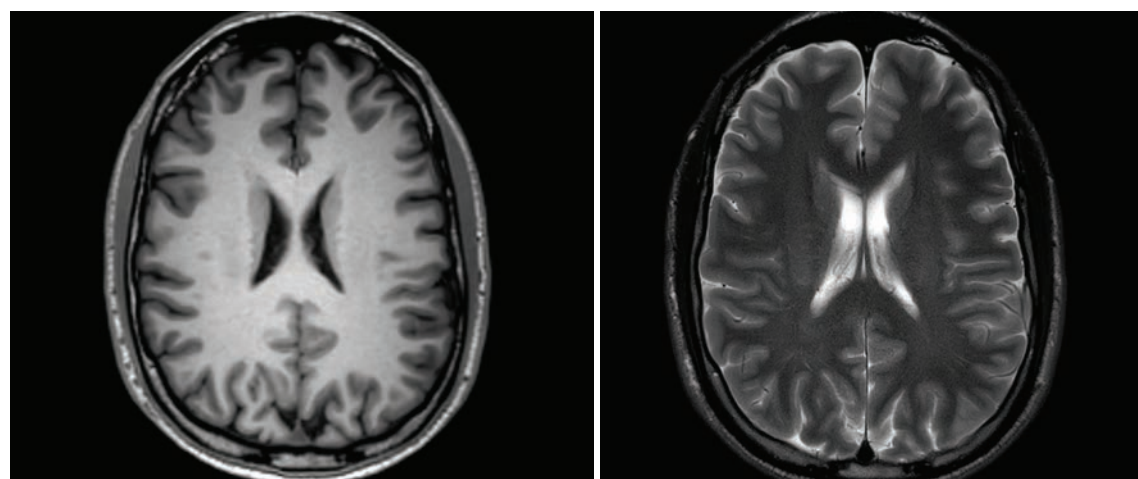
MRI showing mild inflammatory change in the frontal white matter and brainstem.
